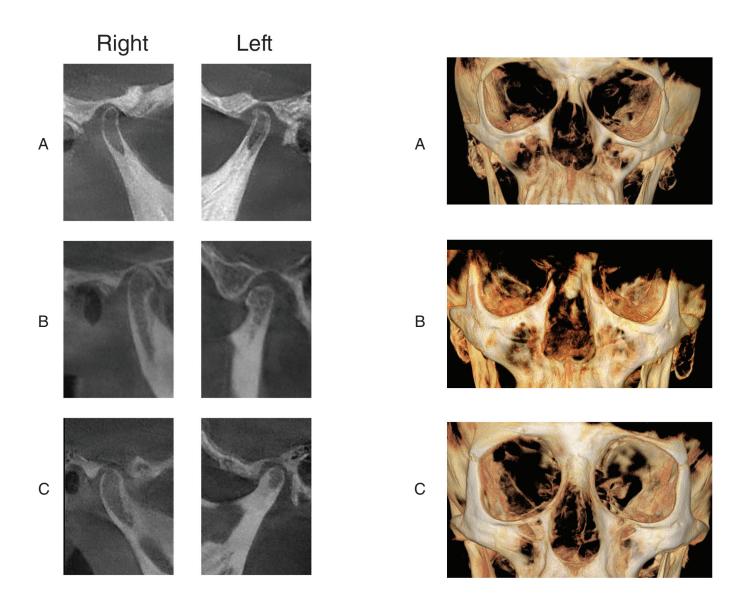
Condyle of a patient with Nemaline Myopathy. Radiographic images show the righ The right and left mandibular condyles of an NM patient (A), a matched open bite (B), and a matched control patient (C). The decrease in size, thinner cortical bone, less trabecular bone, and longer neck differentiate the NM patient from the matched patients.
